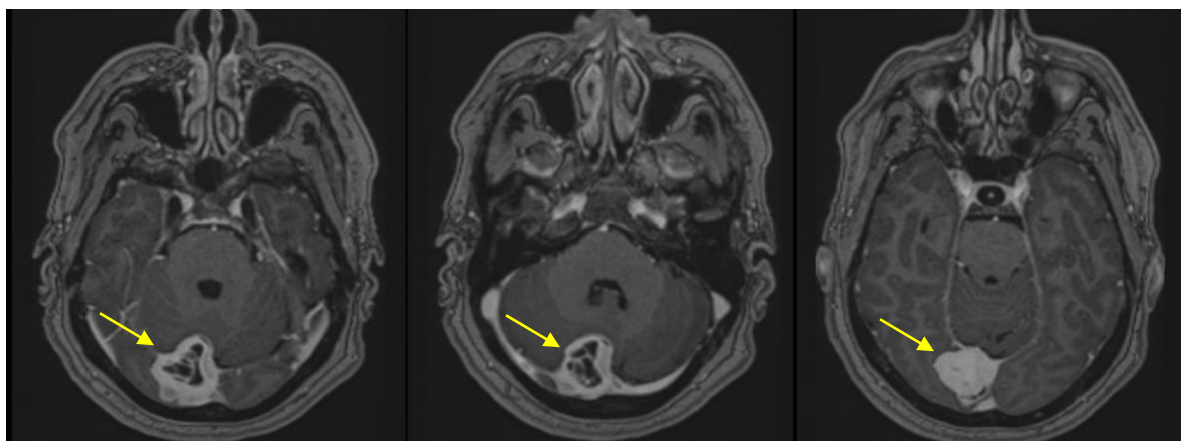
pre-surgery MRI showing the right occipital lesion with homogenous contrast enhancement in axial T1-gadolinium sequence (yellow arrow)
